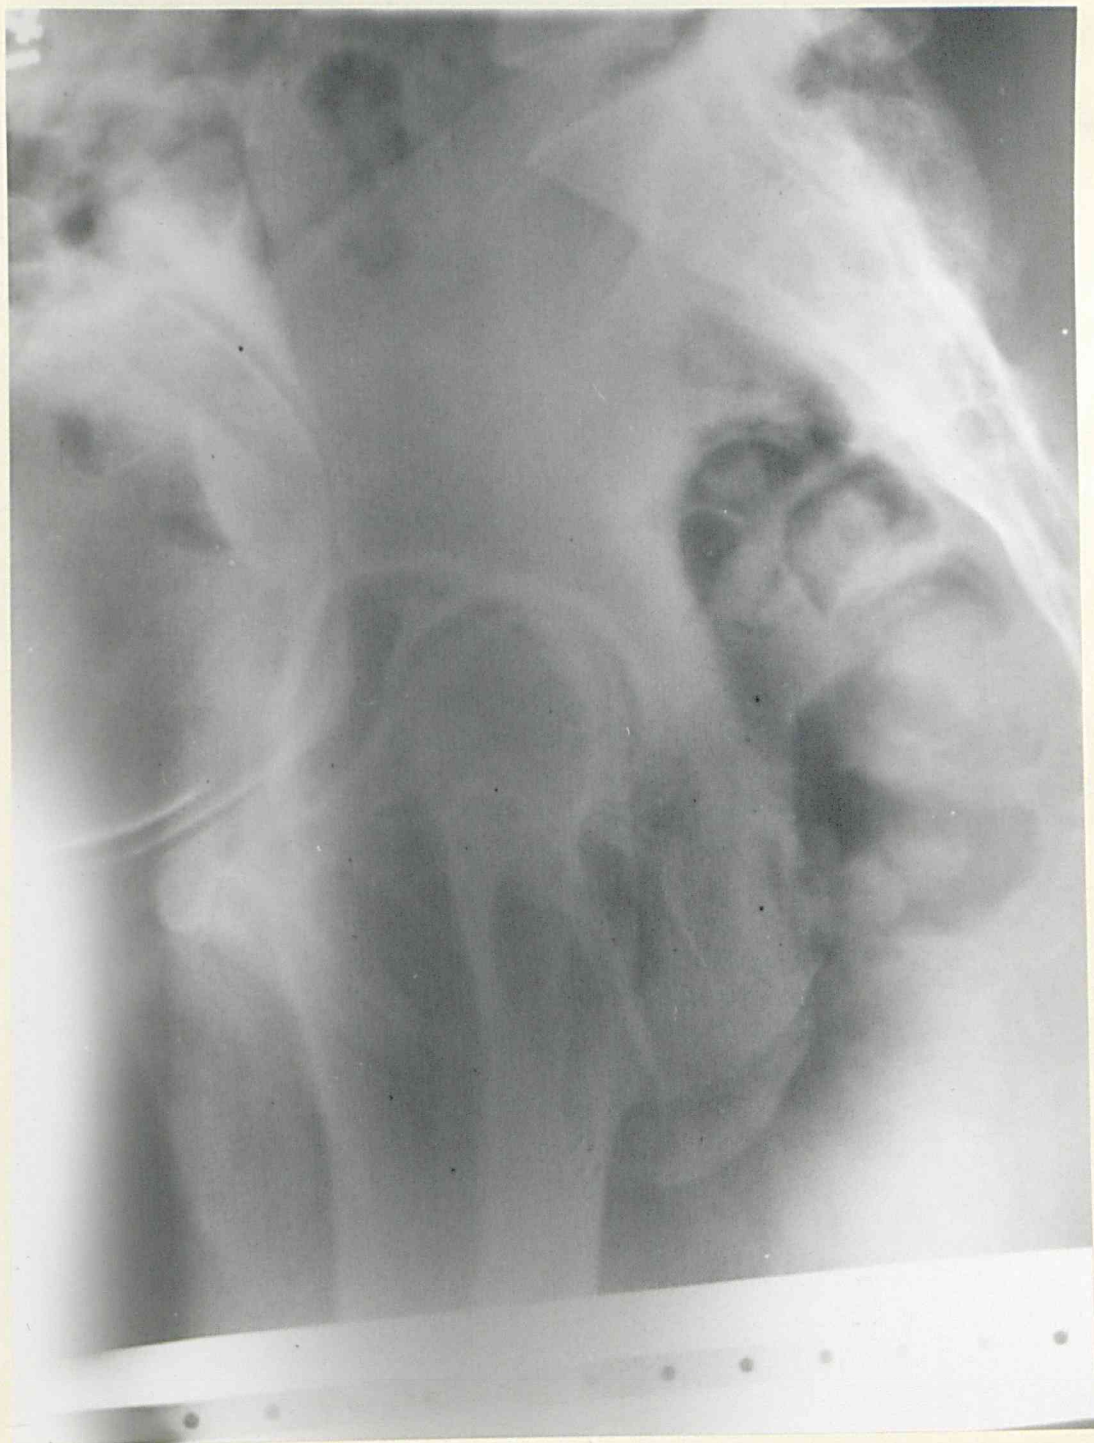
Erect lateral radiograph of the pelvis after amniography in a case of posterior placenta praevia. (The same case as Figure 52). The increased thickness of the "band-like" shadow is shown not to be due to liquor. Figures 52 and 53 are of the same case as Figures 1 and 2.
